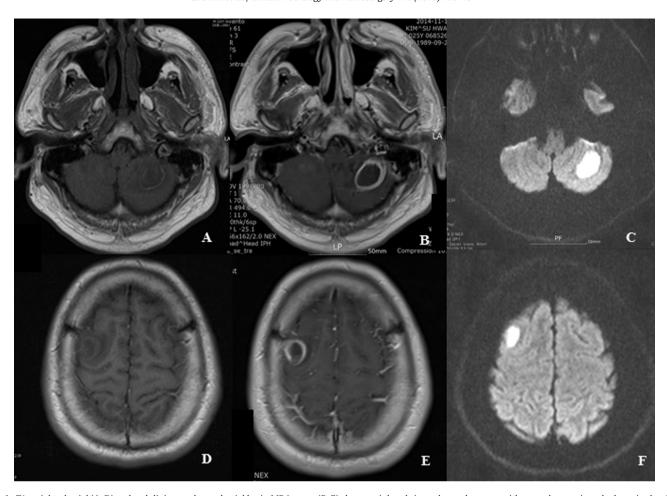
T1 weighted axial (A, D) and gadolinium-enhanced axial brain MR images (B, E) show peripheral rim-enhanced masses with central necrosis and edema in the right frontal lobe $(1.7 \times 1.3 \text{ cm})$ and left cerebellum $(2.6 \times 2.1 \text{ cm})$. Diffusion-weighted images revealed marked diffusion restriction of the mass (C, F).
